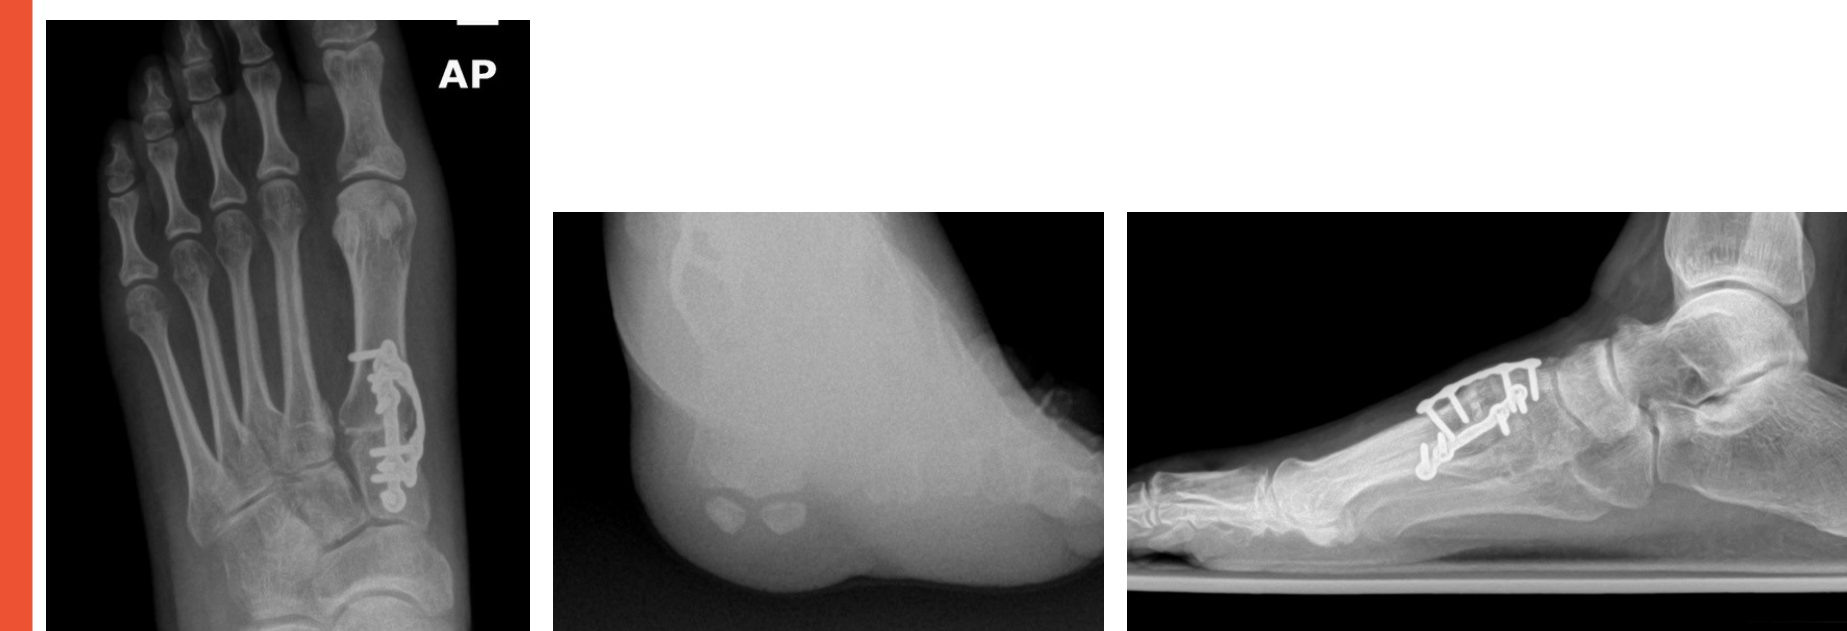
Post-op 3-plane x-rays after triplanar correction.
